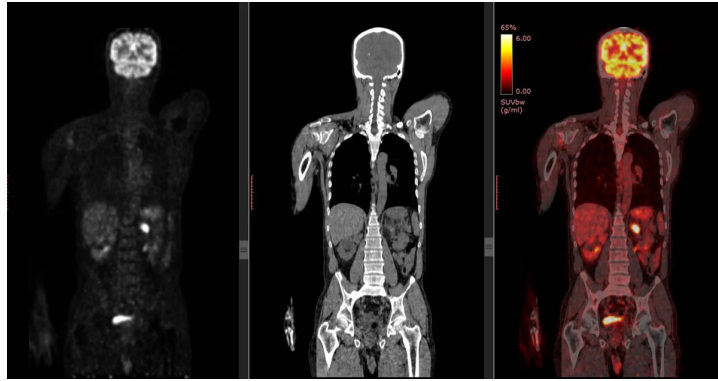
The image shows three example scans of a person from the head to half the femur. The first one (left) is a PET scan highlighting metabolic activity along the body, the second one (center) is a CT scan where tissues structure has a great visibility due to the density differences and the last one (right) is the PET/CT combination which combines the features of both. [62]
